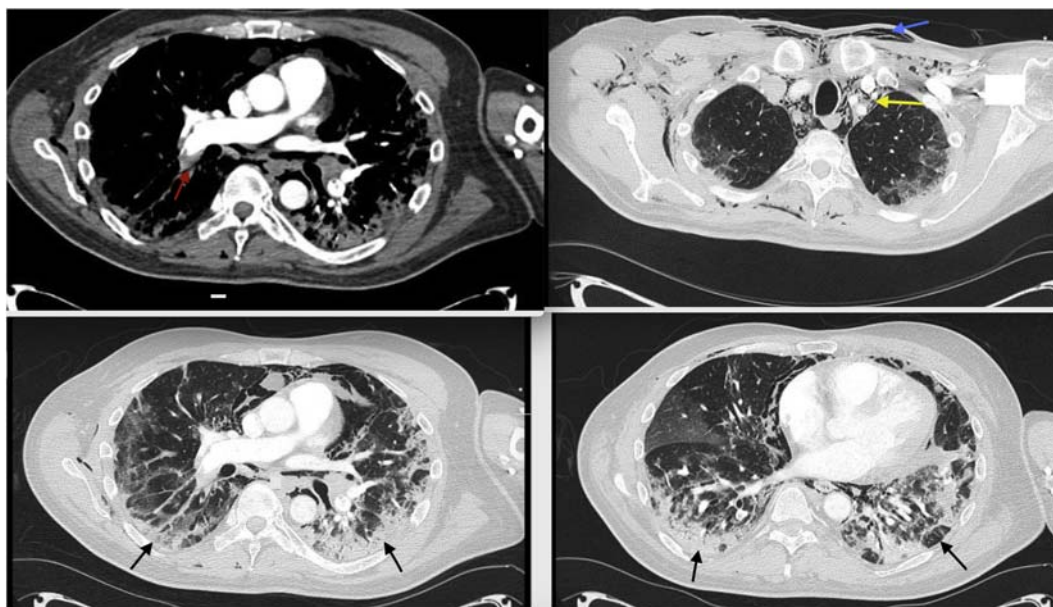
Chest computed tomography angiography scan. Black arrows: bilateral patchy areas of ground glass opacification and consolidation. Red arrow: pulmonary emboli. Blue arrow: extensive subcutaneous emphysema. Yellow arrow: the air in the mediastinum.
